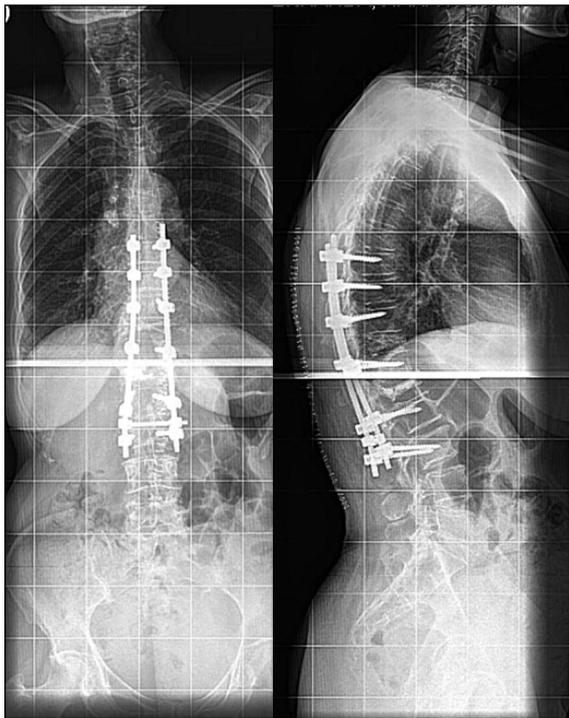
On post-op x-rays a good correction was obtained
